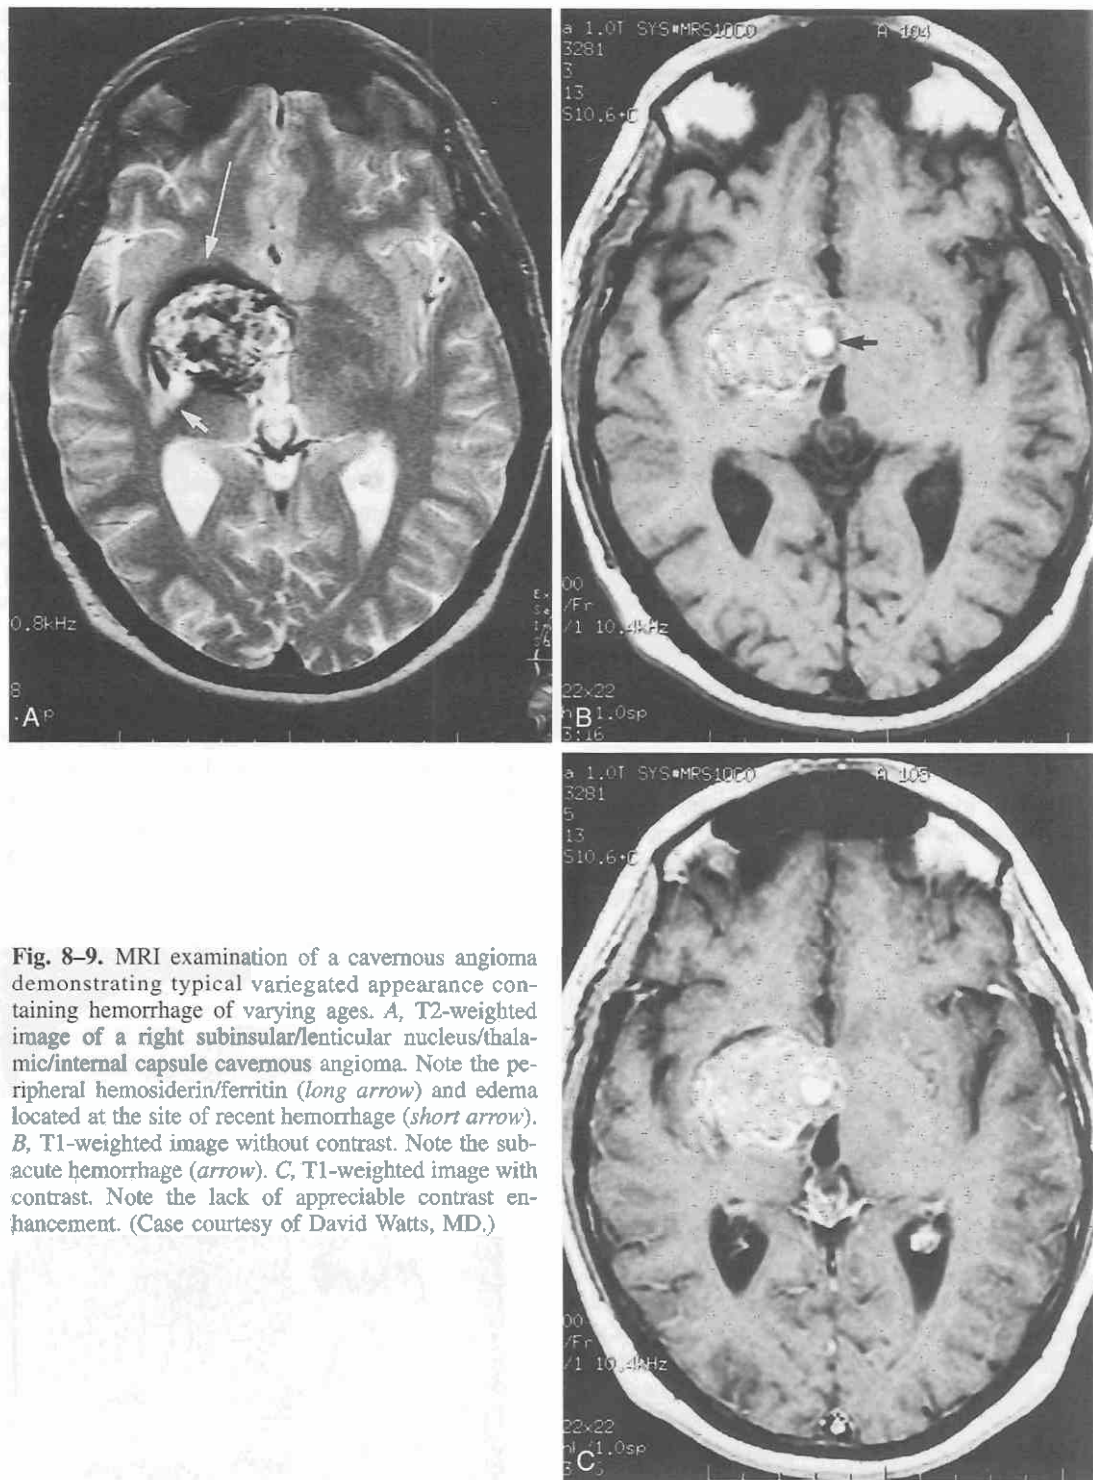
MRI examination of a cavernous angioma demonstrating typical variegated appearance containing hemorrhage of varying ages. A, T2-weighted image of a right subinsular/lenticular nucleus/thalamic/internal capsule cavernous angioma. Note the peripheral hemosiderin/ferritin (*long arrow*) and edema located at the site of recent hemorrhage (*short arrow*). B, T1-weighted image without contrast. Note the subacute hemorrhage (*arrow*). C, T1-weighted image with contrast. Note the lack of appreciable contrast enhancement. (Case courtesy of David Watts, MD.)
